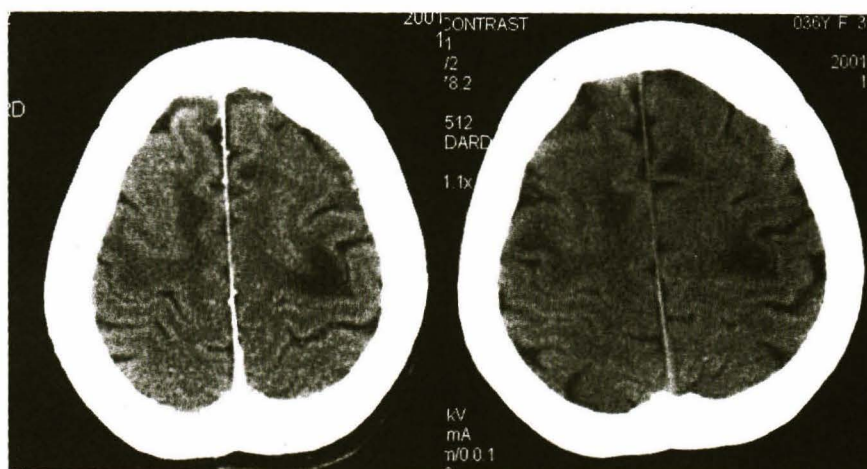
CT scan of the brain (without contrast and with contrast).
